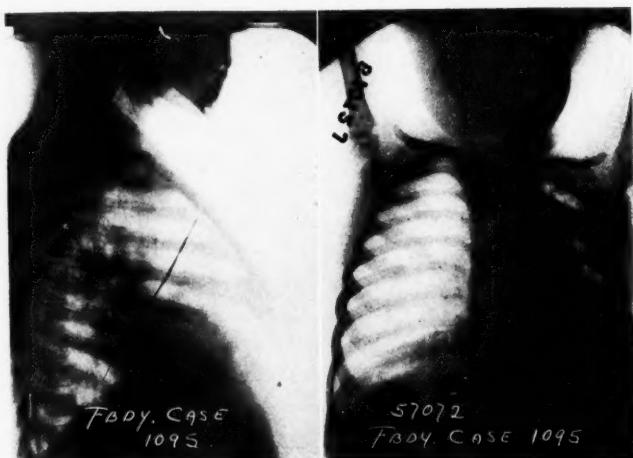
Case II (Fbdy. No. 1095). Roentgenograms, anteroposterior and lateral, of a child aged twenty-three months, showing pulmonary abscess caused by the unknown presence of a screw for twenty months. Removed bloodlessly by bronchoscopy through the mouth without anesthesia, general or local, in three minutes and sixteen seconds. (Films by Dr. Willis F. Manges.)
